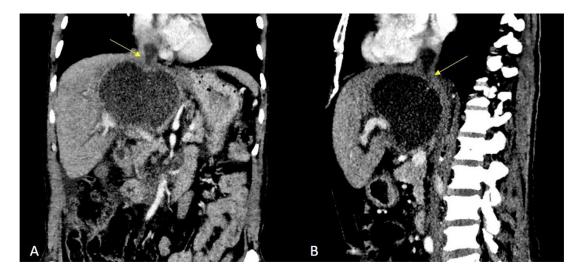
Case 1: Contrast-enhanced CT (A) coronal (B) sagittal showing a hypodense filling defect in the suprahepatic and intrahepatic IVC (yellow arrows).
